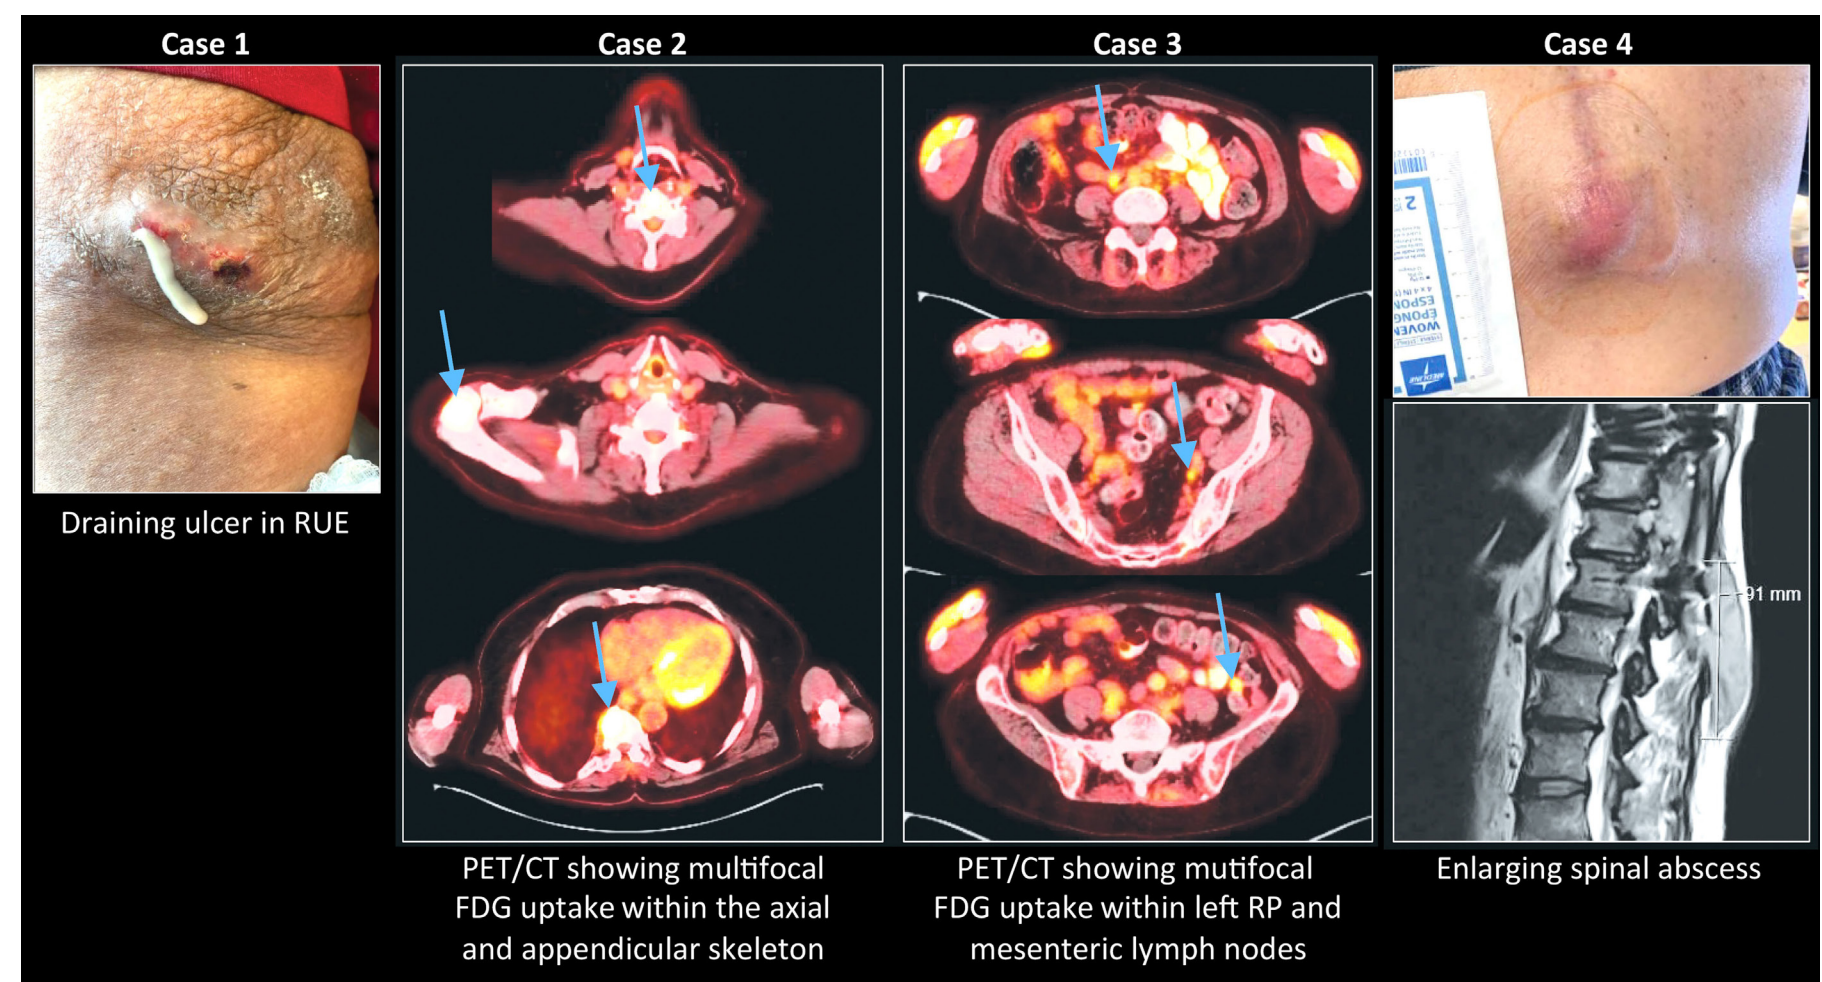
Clinical images. Case 1: draining ulcer in right upper extremity (RUE). Case 2: positron emission tomography/computed tomography scan (PET/CT) showing multifocal fluorodeoxyglucose (FDG) uptake within the axial and appendicular skeleton corresponding to *Mycobacterium avium intracellulare* (MAI) bone infection initially suspicious for progressive lytic lesions. The patient also had FDG uptake in hilar lymph nodes and sub-centimeter pulmonary nodules (not shown). Case 3: PET/CT showing multifocal FDG uptake within left retroperitoneal (RP) and mesenteric lymph nodes corresponding to MAI lymphadenitis masquerading as progressive soft-tissue plasmacytomas. Case 4: enlarging thoracic spinal abscess with corresponding magnetic resonance imaging.
